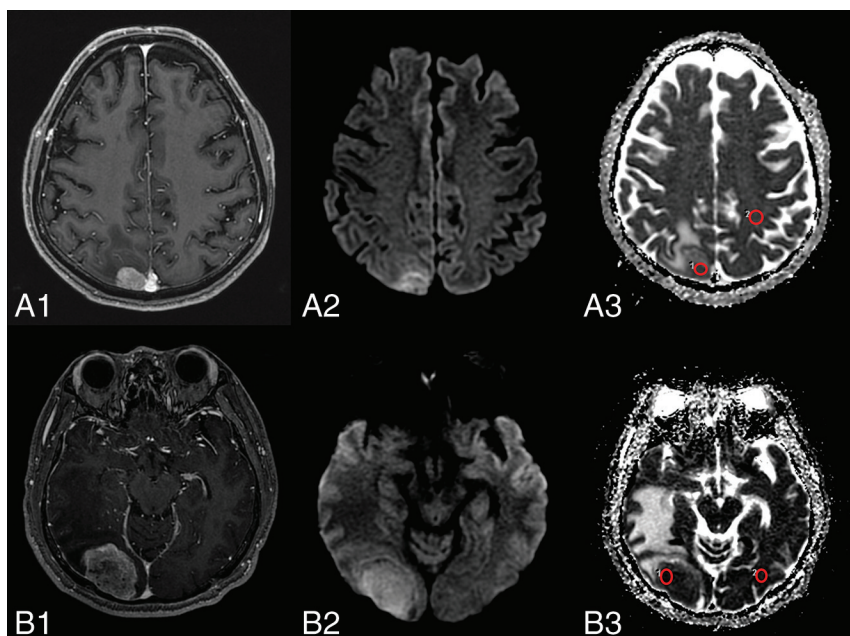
Representative images depicting the ROI within a tumor and the corresponding contralateral normal-appearing white matter for the calculation of apparent diffusion coefficient values for brain metastasis lesions stratified by the *EGFR* mutation status. A1 and B1, Contrast-enhanced T1-weighted images show contrast enhancement of the metastasis. A2 and B2, Diffusion-weighted images show mild-to-moderate high signal intensity in the contrast-enhanced areas. A3 and B3, ADC map with ROIs within the tumor and corresponding contralateral normal-appearing white matter. A1–A3, Wild type *EGFR*. B1–B3, *EGFR* mutation-positive.
